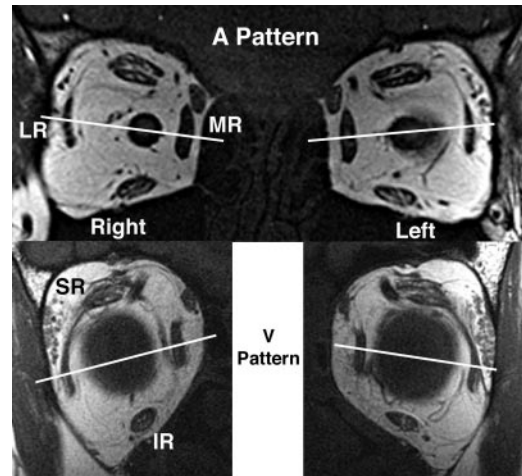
Quasicoronal MRI scans of left and right orbits of two patients with strabismus obtained in central gaze. White lines connect centers of horizontal rectus EOMs just posterior to their pulleys. (A) LR pulleys are superior to the MR pulleys in an A-pattern strabismus. (B) LR pulleys are inferior to MR pulleys in V pattern.
